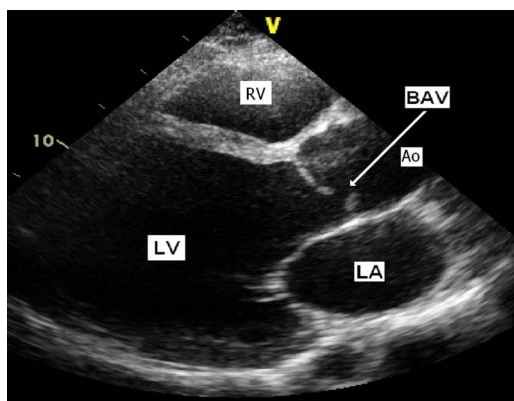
Transthoracic echocardiogram of the proband (subject 'B') showing a severely dilated left ventricle (dimensions of 9.9 cm in diastole and 8.9 cm in systole, normal range 4.2–5.9 cm) and BAV (white arrow) with a typical off-midline closure of leaflets. Left ventricular ejection fraction 14% (normal >55%). Ao, aorta; BAV, bicuspid aortic valve; LA, left atrium; LV, left ventricle; RV, right ventricle.
